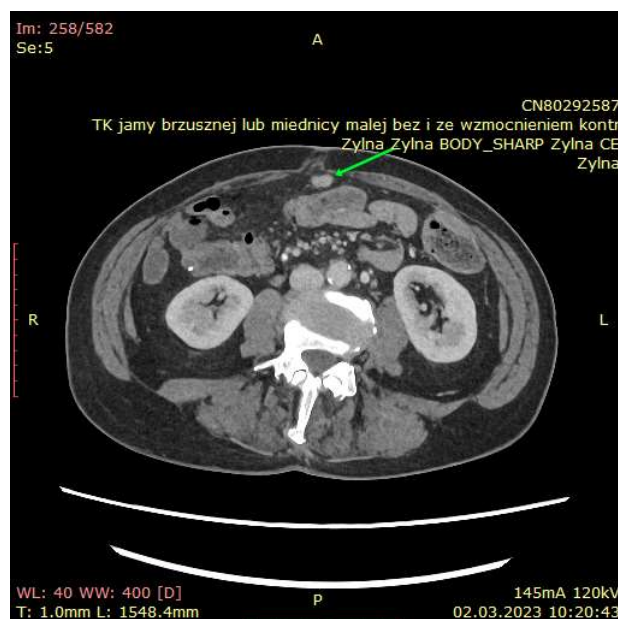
Regression of implants located at the anterior abdominal wall (green arrow), consistent with metastatic colorectal cancer, as observed in the follow-up CT scan dated 02 March 2023.
